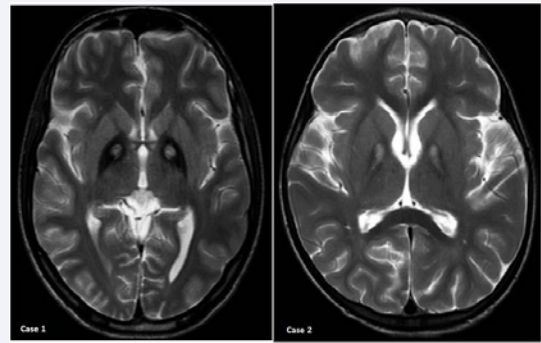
T2-weighted axial brain magnetic resonance images (MRIs) of both the cases shows the classical "eye of the tiger" sign in the globus pallidus.
